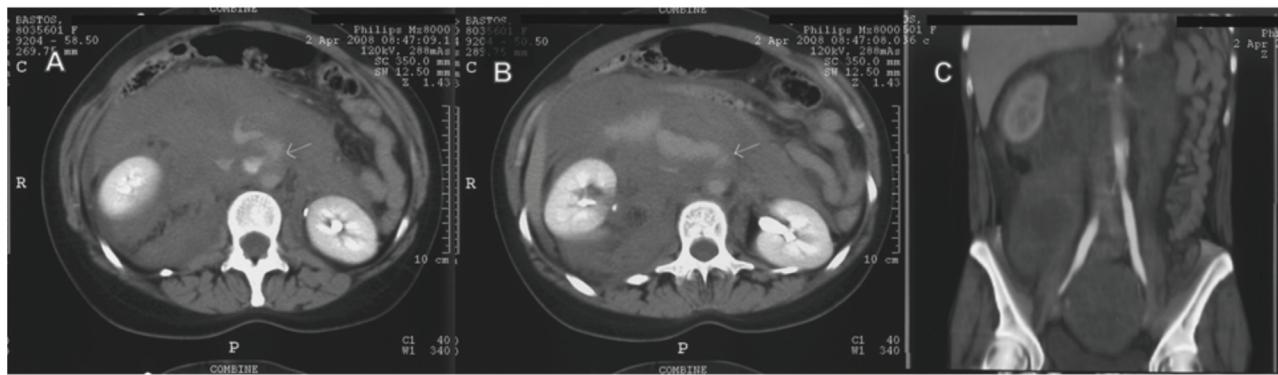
Abdominal computed tomography scan (before surgical intervention). A and B (axial views): spontaneous rupture of the abdominal aorta with active bleeding (big arrow). C (coronal view) revealing the normal caliber of the aorta.
